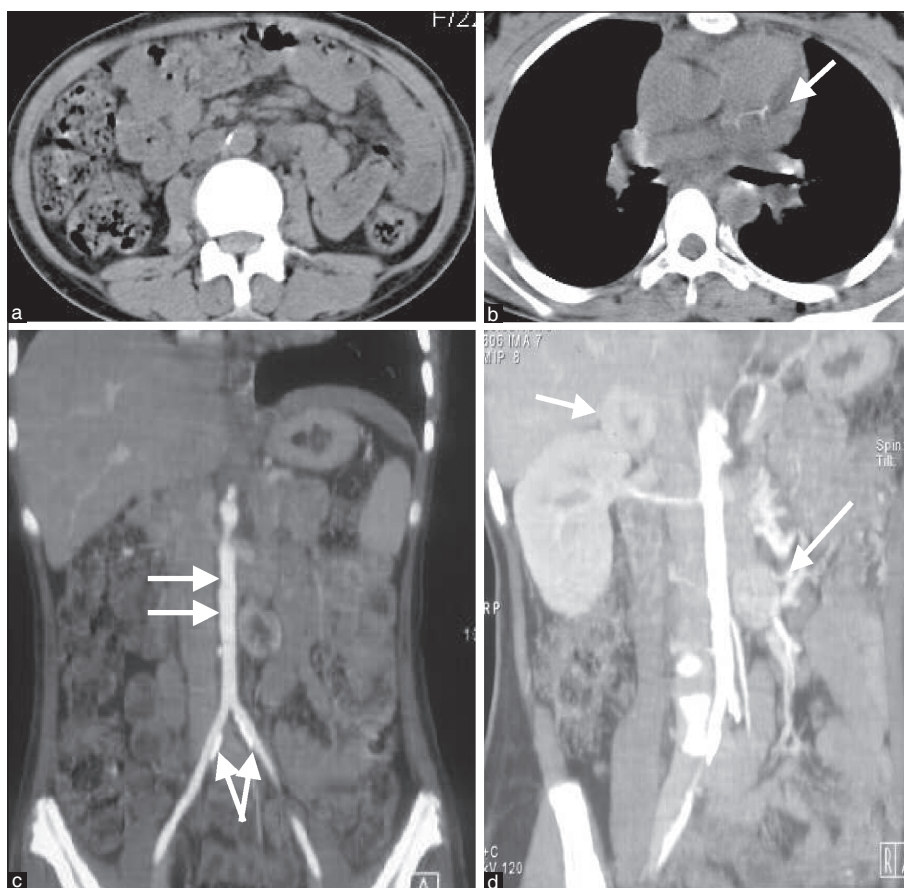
Computerized tomography of Case 2 showing calcification of aorta (a), calcification of coronary artery (b), beaded appearance of aorta on CT angiogram with calcification of both common iliac arteries (c) and right adrenal pheochromocytoma and paraganglioma at left renal hilum (d)
